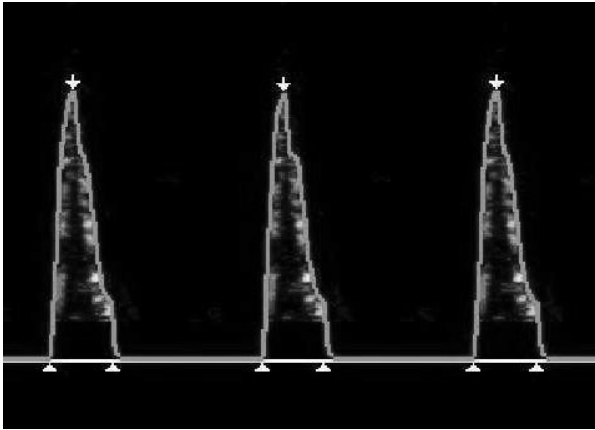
The Doppler waveform in hypovolaemia.
